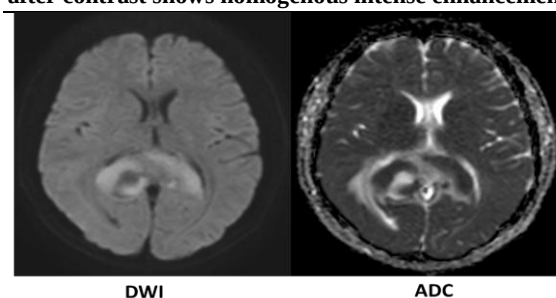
Diffusion-weighted imaging (DWI) reveals restricted diffusion within the tumor, with high signal intensity on DWI and corresponding low signal intensity on the ADC map
